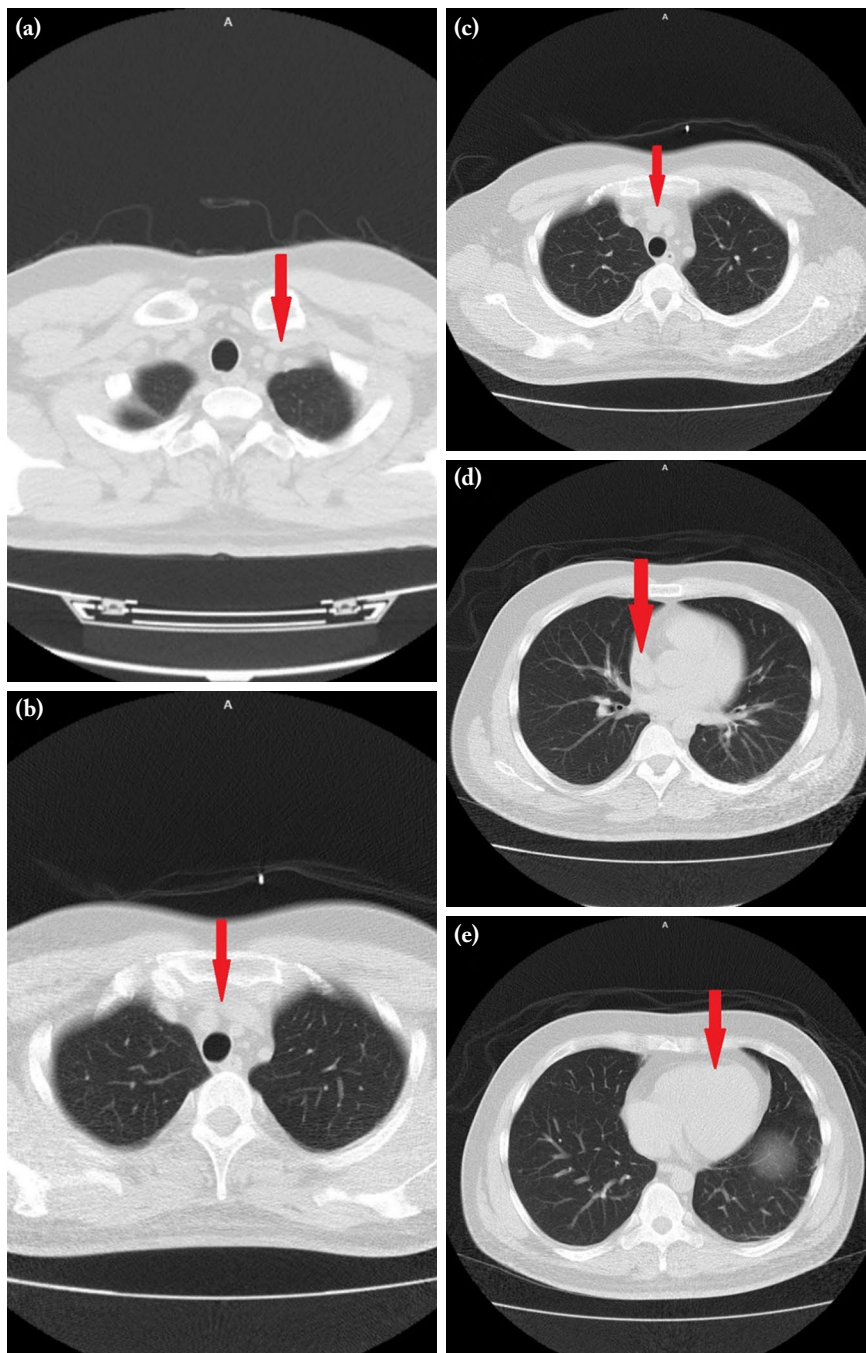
Control computed tomography scan images after 24 h. Non-air image in the (a) left subclavian vein, (b) left brachiocephalic vein, (c) left brachiocephalic vein, (d) vena cava superior, and (e) right ventricle.
